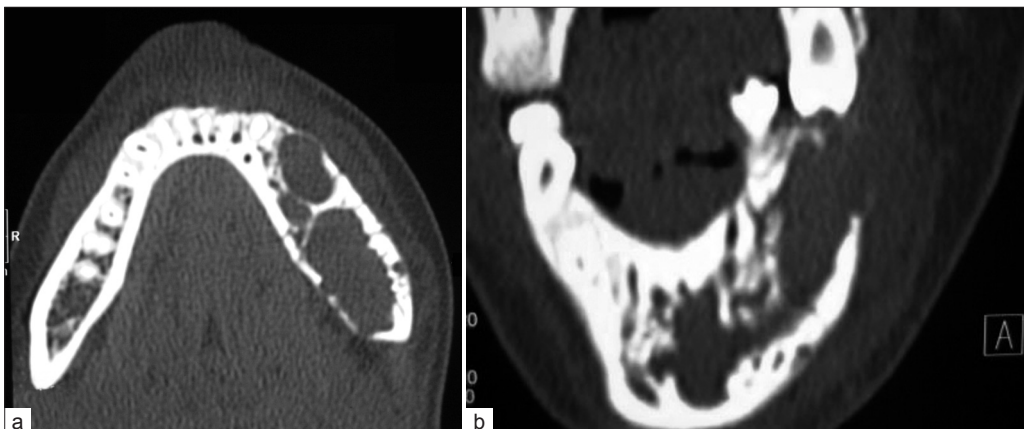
Axial CT and Coronal CT section demonstrating widespread destruction and thinning of cortical plates.
